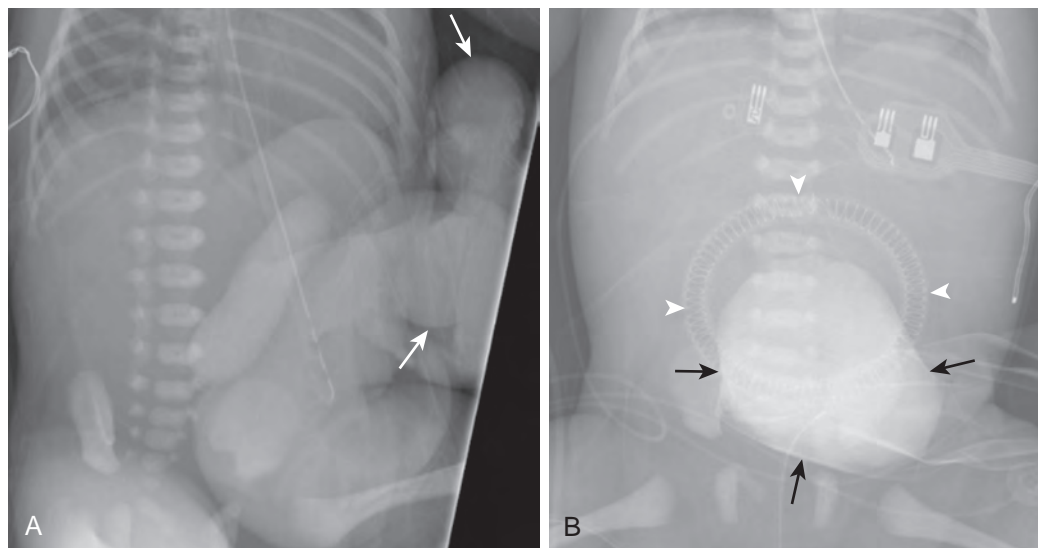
Gastroschisis. A. Frontal radiograph of the abdomen in a newborn with gastroschisis on the first day of life. There are multiple fluid-filled loops of bowel outside of the abdomen (arrows) that do not contain a covering. B. Frontal radiograph of the abdomen in the same patient after silo placement. The bowel loops (arrows) are now contained within the silo covering. The spring within the base of the silo is indicated by arrowheads.
